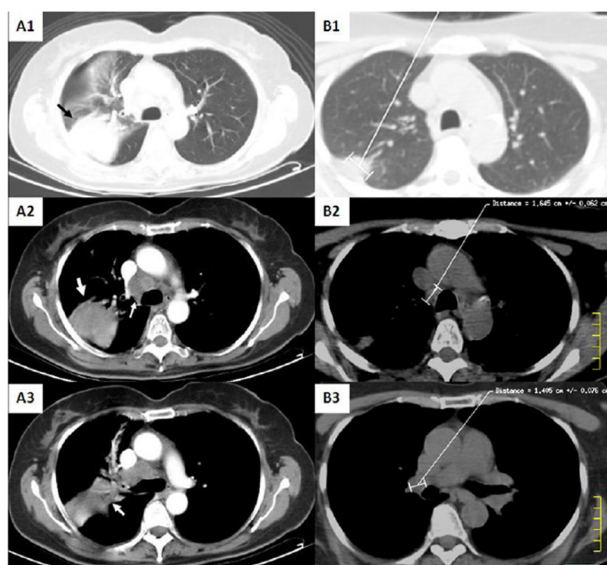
(A1-3, B1-3) - Pre and post-treatment computed tomography (CT) of the thorax. (A1-3) Pre-treatment CT of the thorax with intravenous contrast (A1) Subpleural pulmonary mass in the upper right lobe (arrow), with maximum diameter of 61 mm. (A2) Pulmonary mass (large arrow) and mediastinal right paratracheal enlarged lymph node (thin arrow), with maximum diameter of 26 mm. (A3) Right perihilar enlarged lymph node (arrow), considered as a non-measurable lesion on CT, due to its proximity to the primary tumor. (B1-3) Post-treatment CT of the thorax without intravenous contrast (B1) Residual pulmonary mass in the upper right lobe, with maximum diameter of 22 mm. (B2) Right paratracheal mediastinal enlarged lymph node, with maximum diameter of 16 mm. (B3) Right perihilar enlarged lymph node, with maximum diameter of 14 mm.
